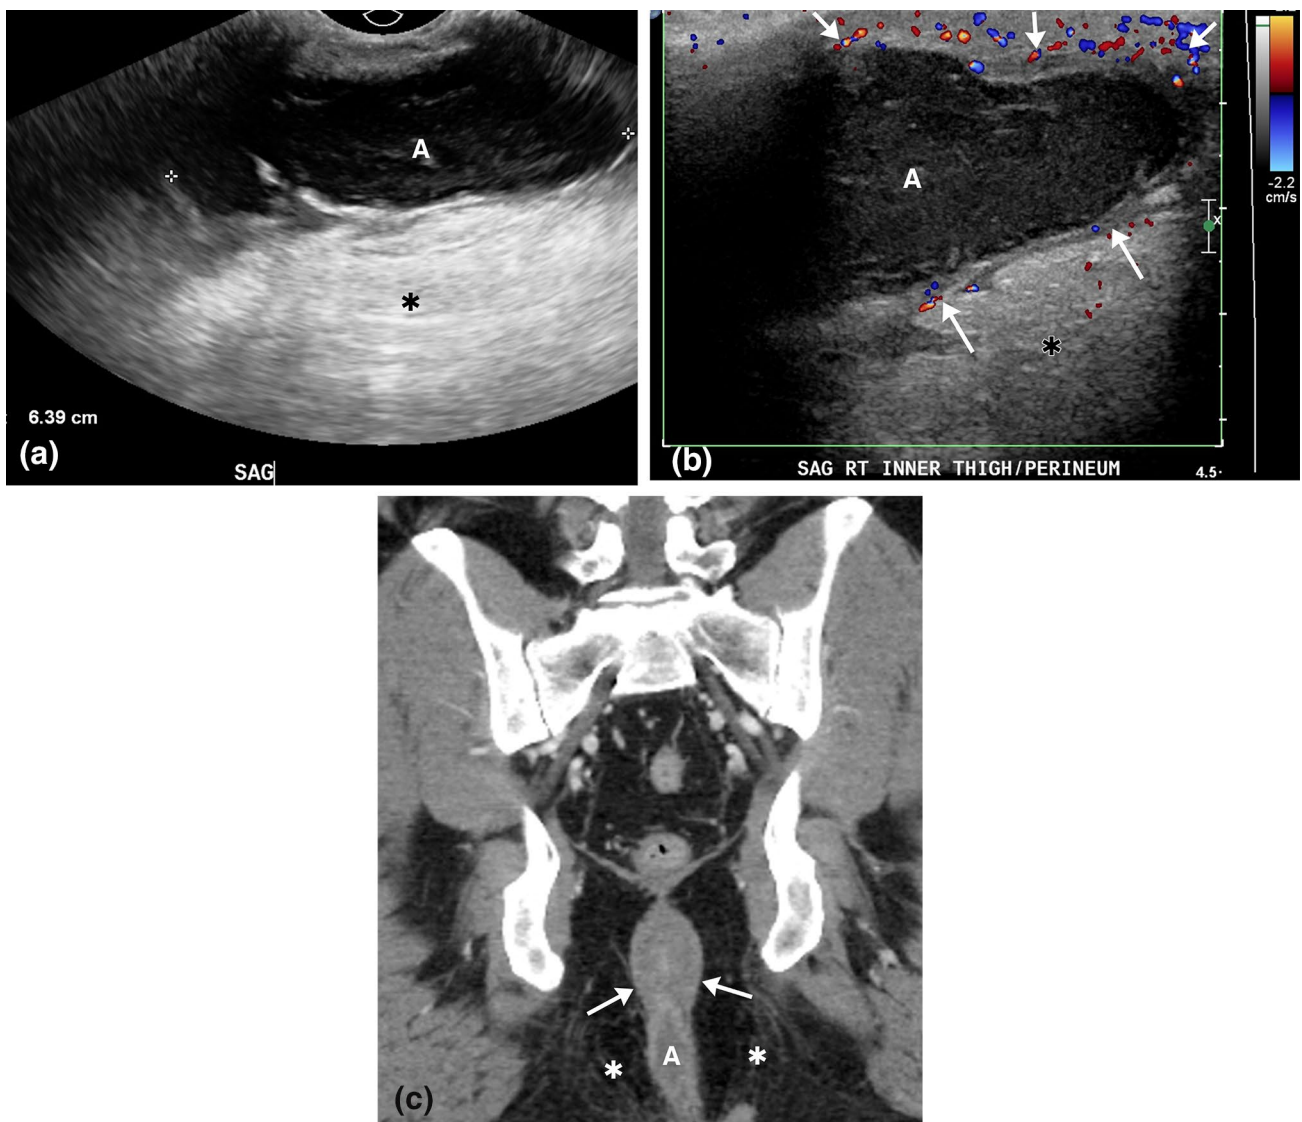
Large abscess in the right inner thigh/perineum with associated fistula track extending to the anus in a 43-year-old male presenting with pain in the perineum. a, b Gray scale and color Doppler images obtained in sagittal plane via transperineal approach demonstrate a complex fluid collection compatible with an abscess (a). Marked peripheral hyperemia is noted in the soft tissues adjacent to
